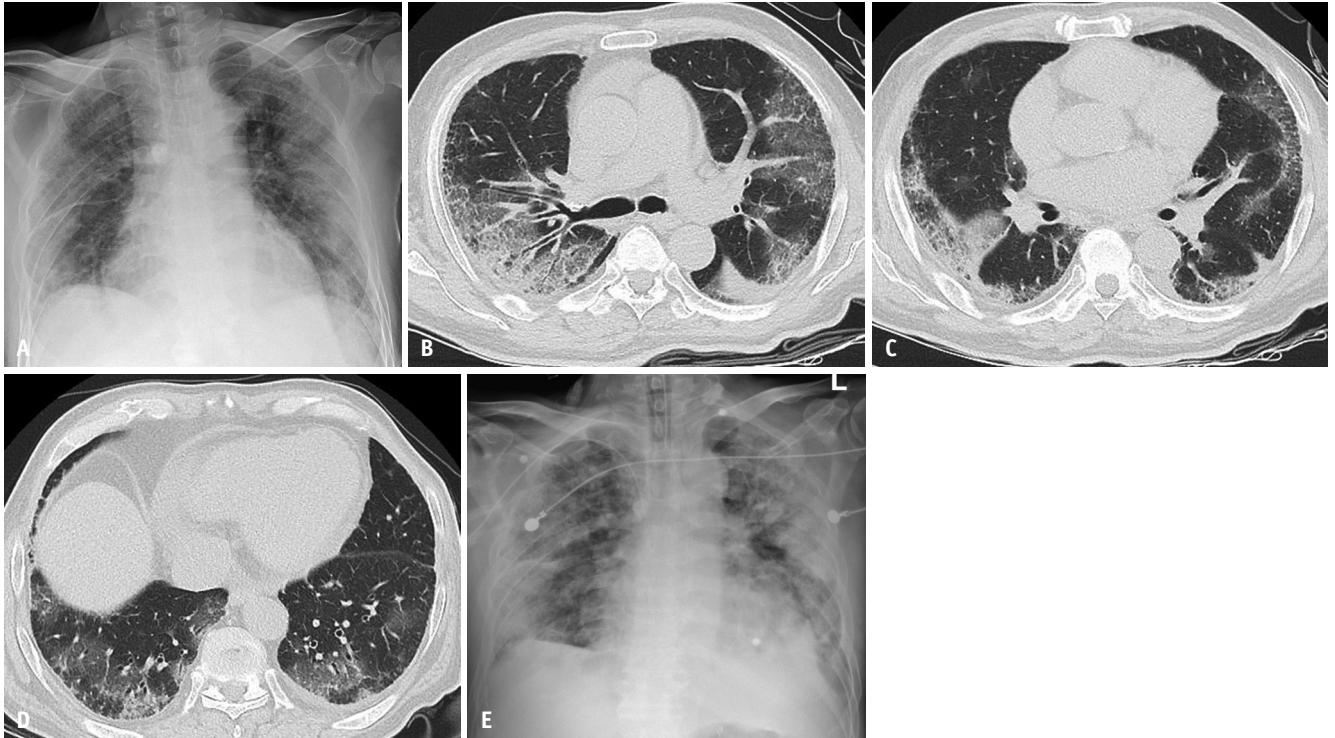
A case of COVID-19 pneumonia during the Delta variant-dominant period in a 67-year-old male patient with malignant lymphoma. A: Initial chest radiograph showing a multifocal area of GGO at the peripheries of the bilateral lungs. The case was classified as ‘severe pneumonia’ ($\geq 25\%$ lung involvement) based on the modified 3-point visual scoring system. B-D: Lung window images of a transverse non-enhanced chest CT scan obtained at admission showing multifocal areas of GGO and consolidation with intralobular interstitial thickening (crazy-paving pattern) involving the bilateral lungs with subpleural predominance. CT findings were classified as “typical” according to the Radiological Society of North America chest CT classification system. E: Follow-up chest radiographs obtained on hospital day 10 demonstrating GGO progression in the bilateral lungs. The patient underwent mechanical ventilation 2 days later, but died of acute respiratory distress syndrome. GGO = ground-glass opacity
